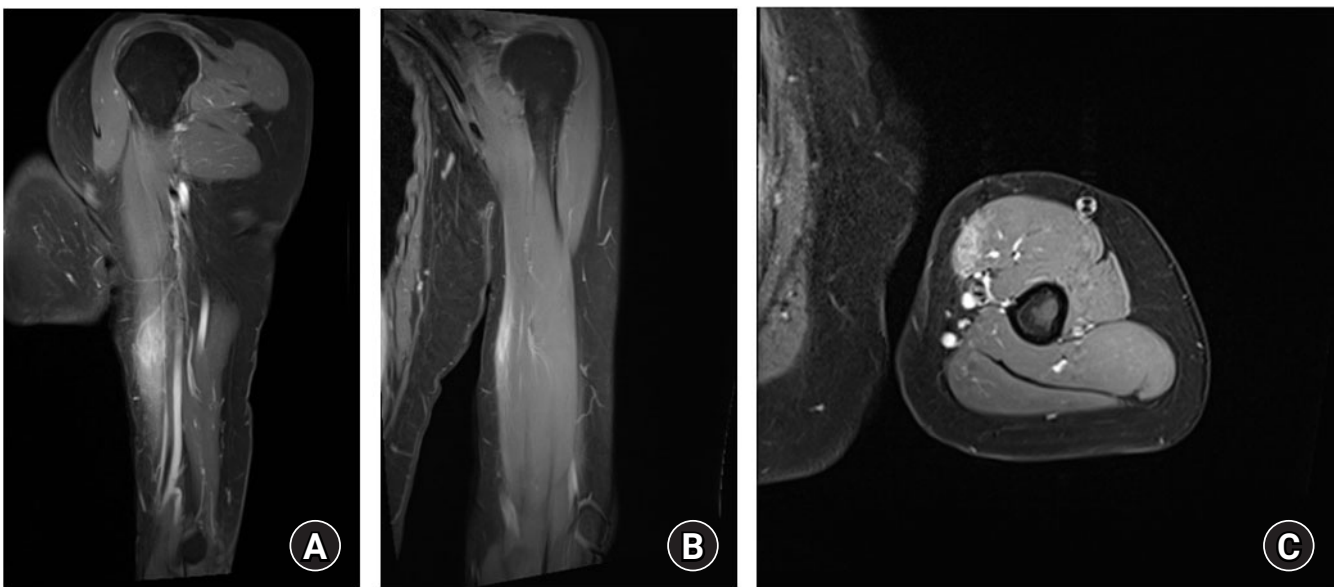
Initial magnetic resonance imaging of the upper extremity with enhancement (A, sagittal; B, coronal; C, axial view). Approximately 3×3-cm-sized ill-defined intramuscular lesion with prominent signal enhancement on the biceps brachii muscle of the left arm on T1-weighted enhanced imaging.
